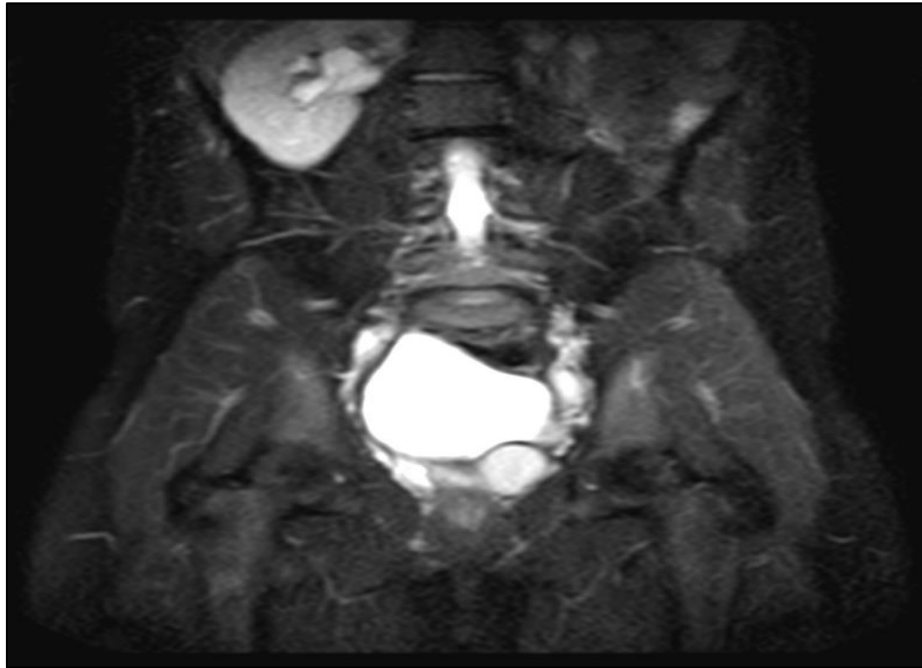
Coronal MRI Showing T2 Hyperintense Left Seminal Vesicle Cyst Abutting the Base of the Bladder
